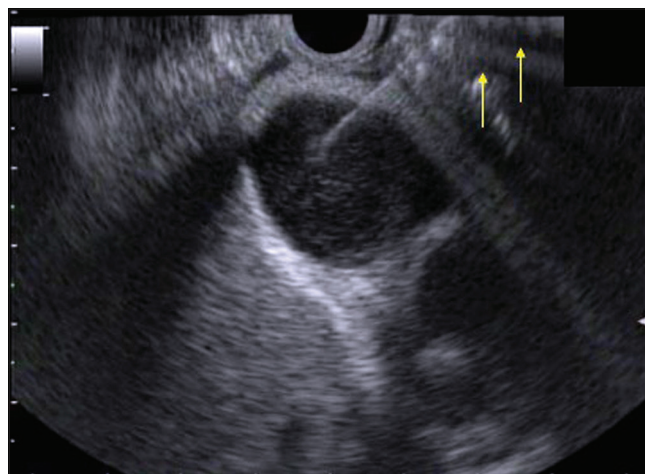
Endoscopic ultrasound imaging shows puncture of the gallbladder using a 19G needle (arrow; the stomach and duodenum wall)
